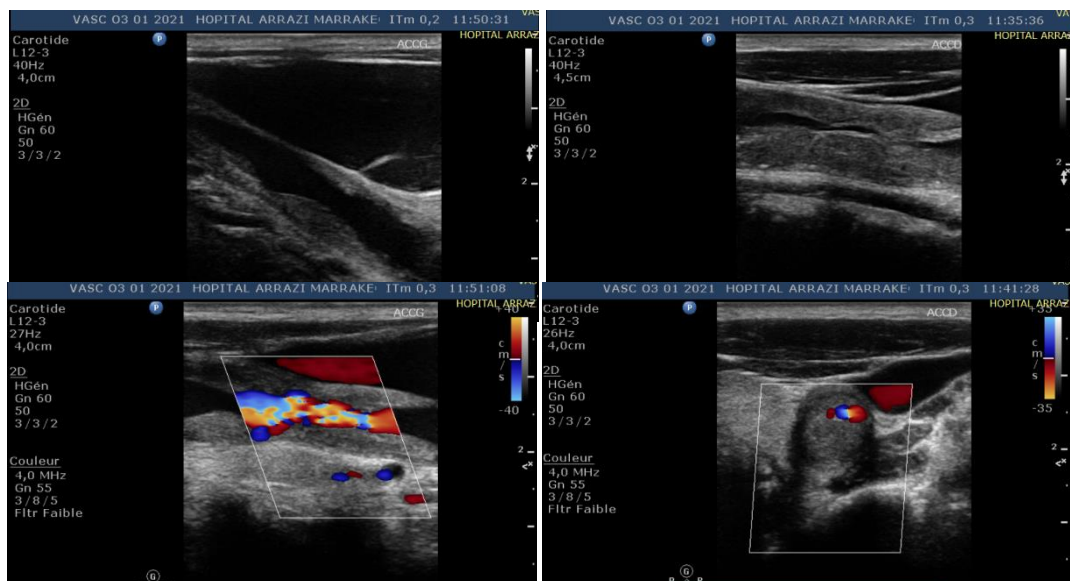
Doppler ultrasound of the supra-aortic trunks revealed common carotid arteries hosting extensive plaques along their entire length, with a very tight stenosis in the right common carotid and a tight stenosis in the left common carotid.
